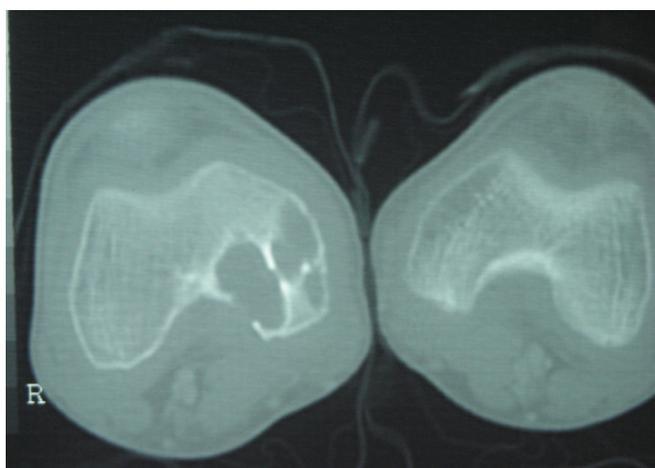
CT clearly shows the relation of the lytic lesions at the distal epiphysis of the right femur with the articular surface.
